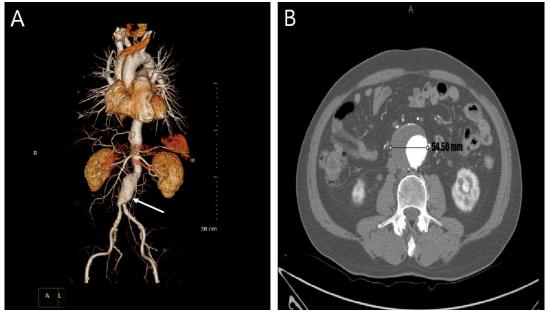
Computed tomography (CT) showing infra-renal abdominal aortic aneurysm (A) with a diameter of 54.50mm (B)
